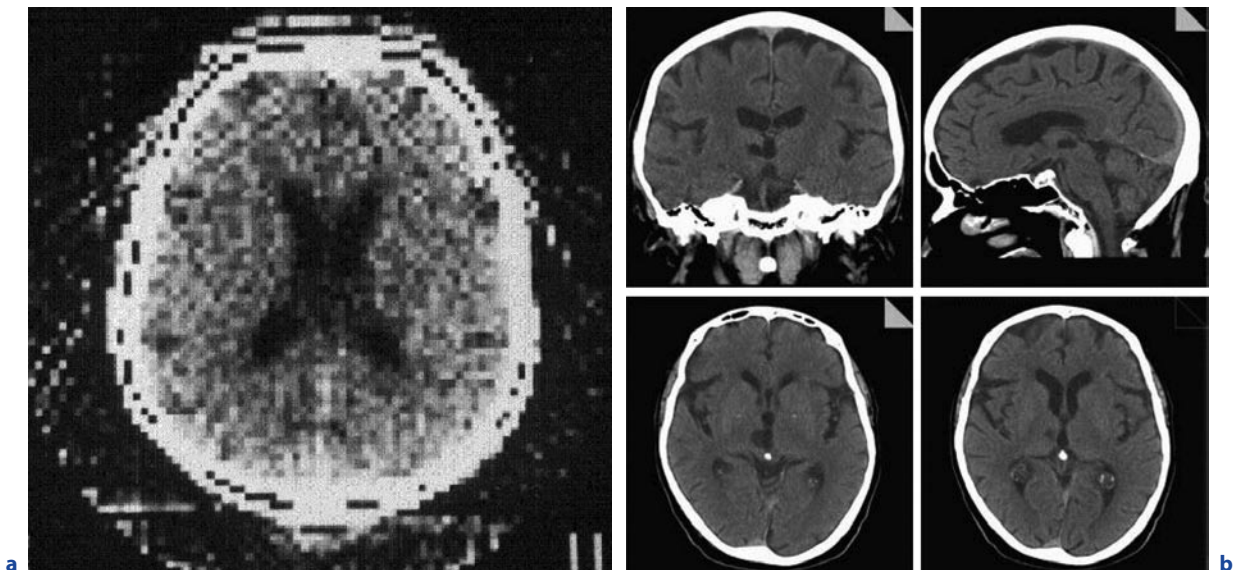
Development of computed tomography over time. a Cross-sectional image of a brain in the year 1971 and (b) the whole brain with sagittal, coronal and cross-sectional slices in the year 2007. (Image courtesy of Mayo Clinic Rochester)
